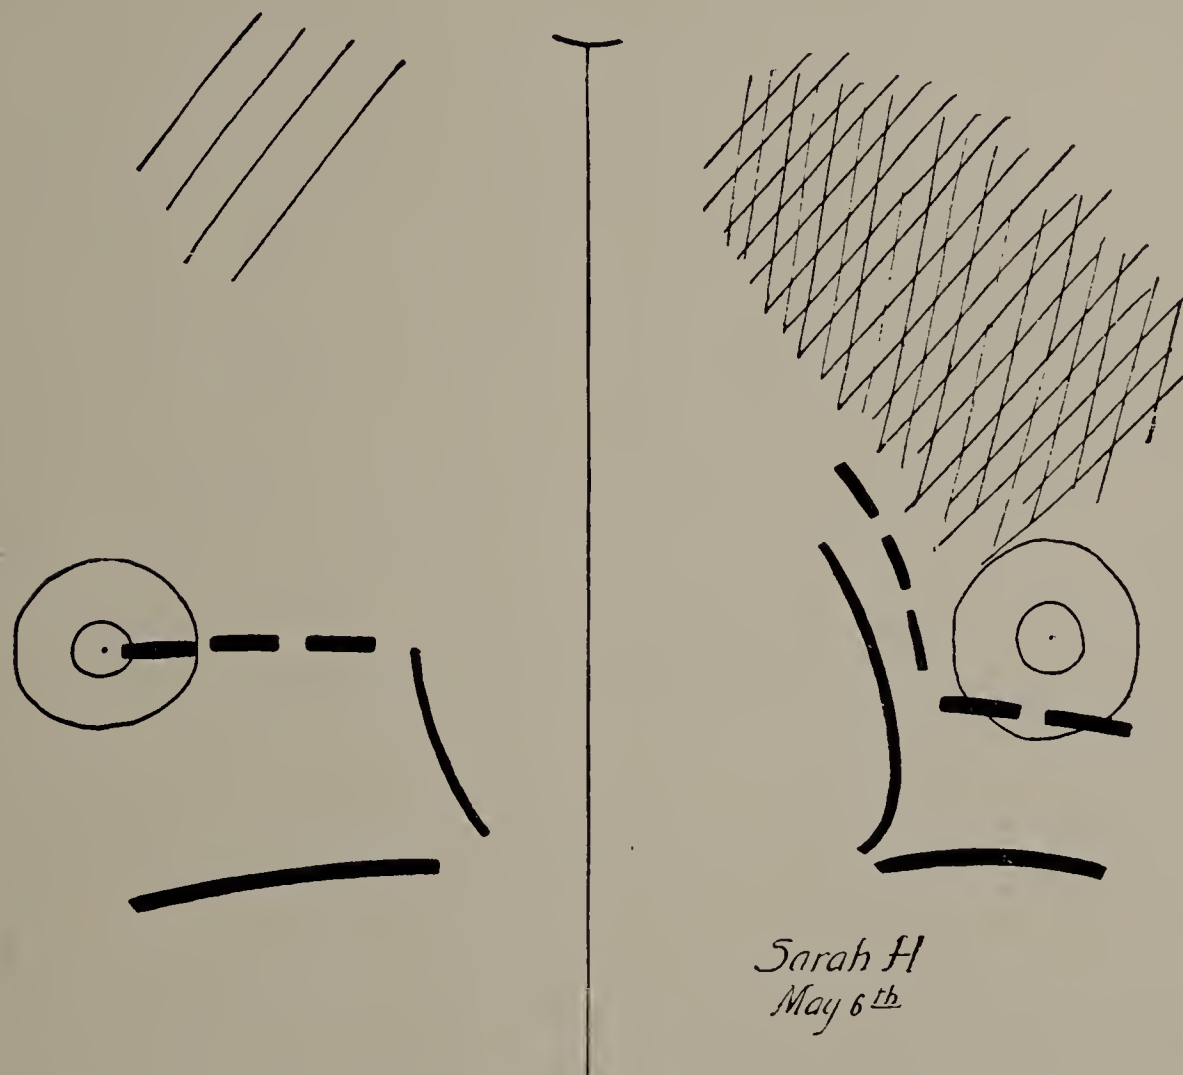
Sarah H. May 6, 1898. Second X-ray tracing. Increase in darkened area of left lung and right apex also shaded. Excursion of diaphragm on left side, 3.7 centimetres (1.25 centimetres shorter than on April 24); on right side, 5.3 centimetres (1.25 centimetres shorter on this side also than on April 24). (One-third life size.)
